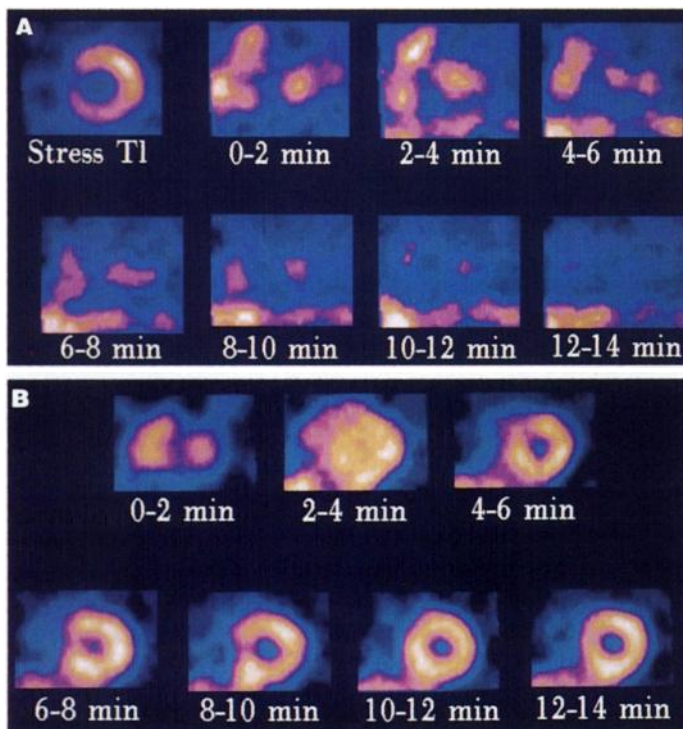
Serial short-axis tomograms in the dynamic SPECT studies with BMIPP (seven series of 2-min acquisitions). (A) A patient (M.S.) with absence of myocardial BMIPP uptake in both the early and late imaging shows no myocardial uptake in all of seven images acquired during the 14 min after injection. A ^{201}Tl short-axis tomogram obtained immediately after exercise testing is also shown. The blood activity in the right and left ventricular cavities gradually decreases in the BMIPP images. (B) Another patient with myocardial BMIPP uptake in both the early and late imaging shows a significant uptake in the left ventricular myocardium from 4 min after injection.
